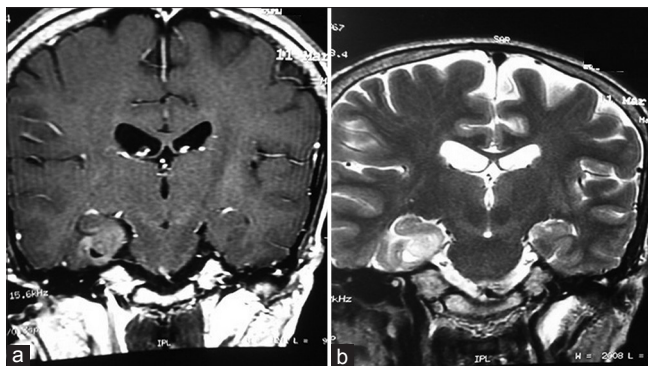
Magnetic resonance imaging showing (a) solid cystic lesion, hyperintense on T1 postcontrast and (b) T2 weighted images in the right medial temporal lobe within the parahippocampal gyrus
